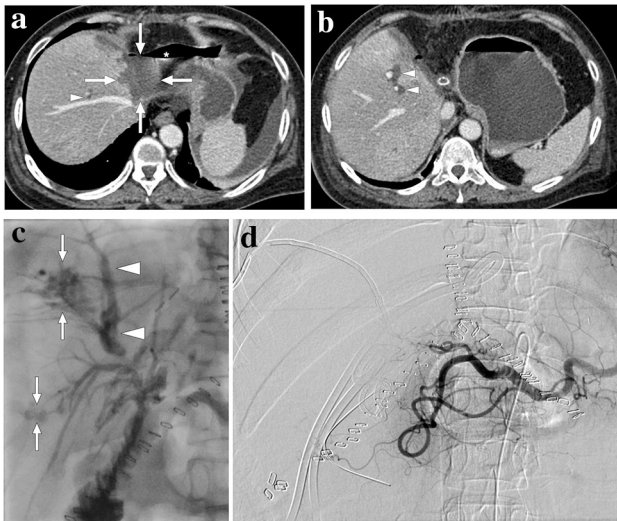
A 55-year-old female patient with a 2-year history of primary sclerosing cholangitis underwent right liver lobe transplantation from a living donor. On day 4 after the transplantation surgery, the abdominopelvic CT exam was within normal limits (not shown). On day 10, bile containing serous fluid leakage was observed through the abdominal incision scar. a and b Axial plane postcontrast abdominal CT images showed a newly developed collection (arrows) containing air–fluid levels (asterisk) along the resection line between the liver and stomach, which was found to represent a biloma. Mild dilatation in the intrahepatic bile ducts was also observed (arrowheads). Subsequent percutaneous transhepatic cholangiography (PTC) demonstrated leakage from the biliary anastomosis site, and percutaneous biliary drainage was subsequently performed. During follow-up, serum bilirubin levels increased progressively despite adequate biliary drainage. c Three months after the transplantation, follow-up PTC revealed dilatation of intrahepatic bile ducts (arrowheads) and leakage of contrast medium into the periportal space (arrows). d To rule out ischemic cholangiopathy, invasive angiography was performed, which revealed the complete occlusion of the hepatic artery. Unfortunately, the patient's clinical condition deteriorated progressively, and the patient expired due to biliary sepsis 2 weeks after the angiography
